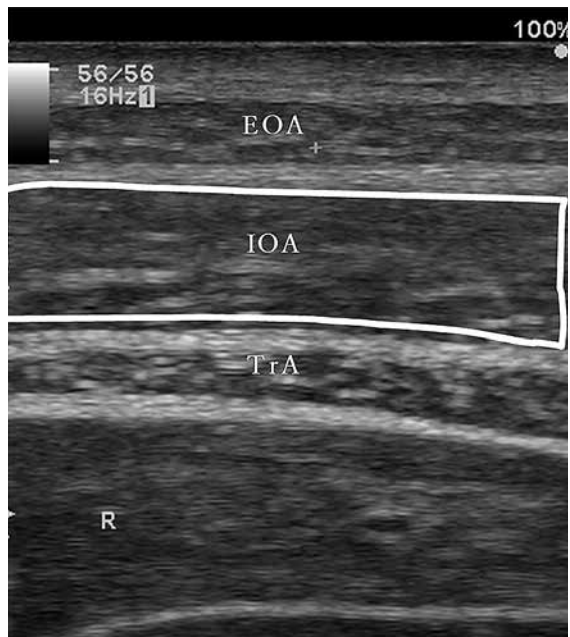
Ultrasound image of abdominal muscles of a healthy subject. From above External oblique abdominis (EOA), Internal oblique abdominis (IOA), Transverse abdominis (TrA). The echo intensity of Internal oblique muscle was measured as a range which is surrounded by white.
